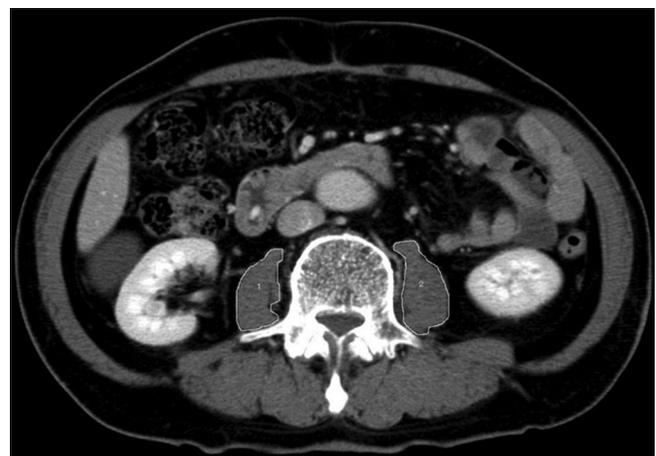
Cross sectional area (cm^2) of the psoas muscle at the level of the third lumbar vertebra (L3) measured by manual tracing on computed tomography
